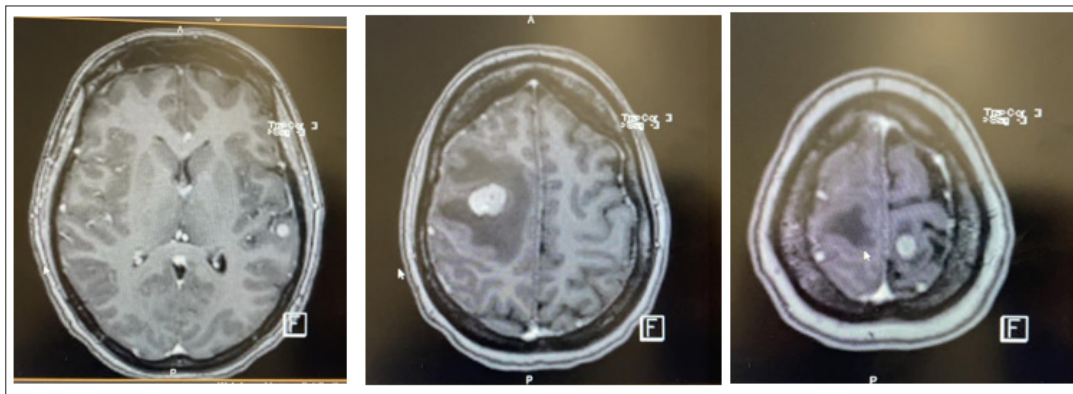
MRI brain March 2018 (Axial view) showing multiple metastatic lesions in both hemispheres with largest lesion in the right posterior frontal lobe measuring 2cm with mass effect and a 2.6mm midline shift.
